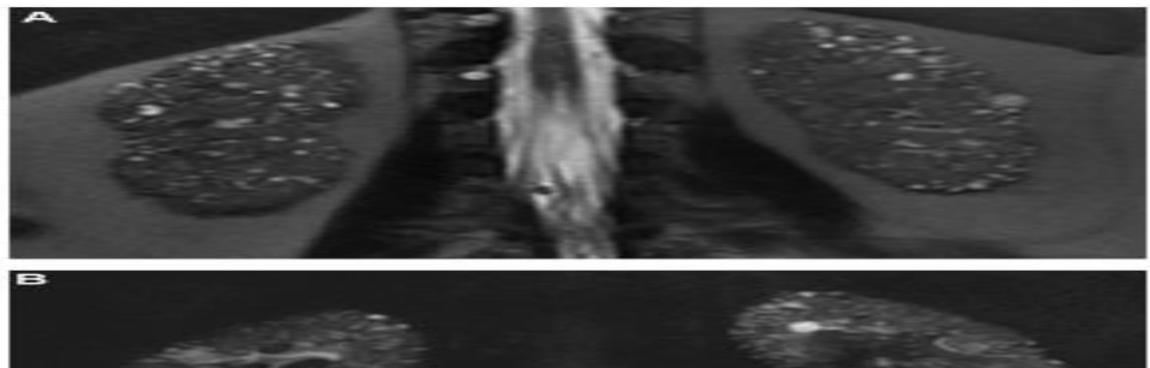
Magnetic resonance (MR) images of the kidneys in a 59-year-old woman who has been receiving lithium treatment for more than 20 years. A. Fat attenuated T2-weighted MR image in the coronal plane (TR/TE-1250/90 msec). B. Fat attenuated heavily T2-weighted MR image in the coronal plane (TR/TE-6000/600 msec) show multiple, hyperintense microcysts in the cortex and medulla of both kidneys.
